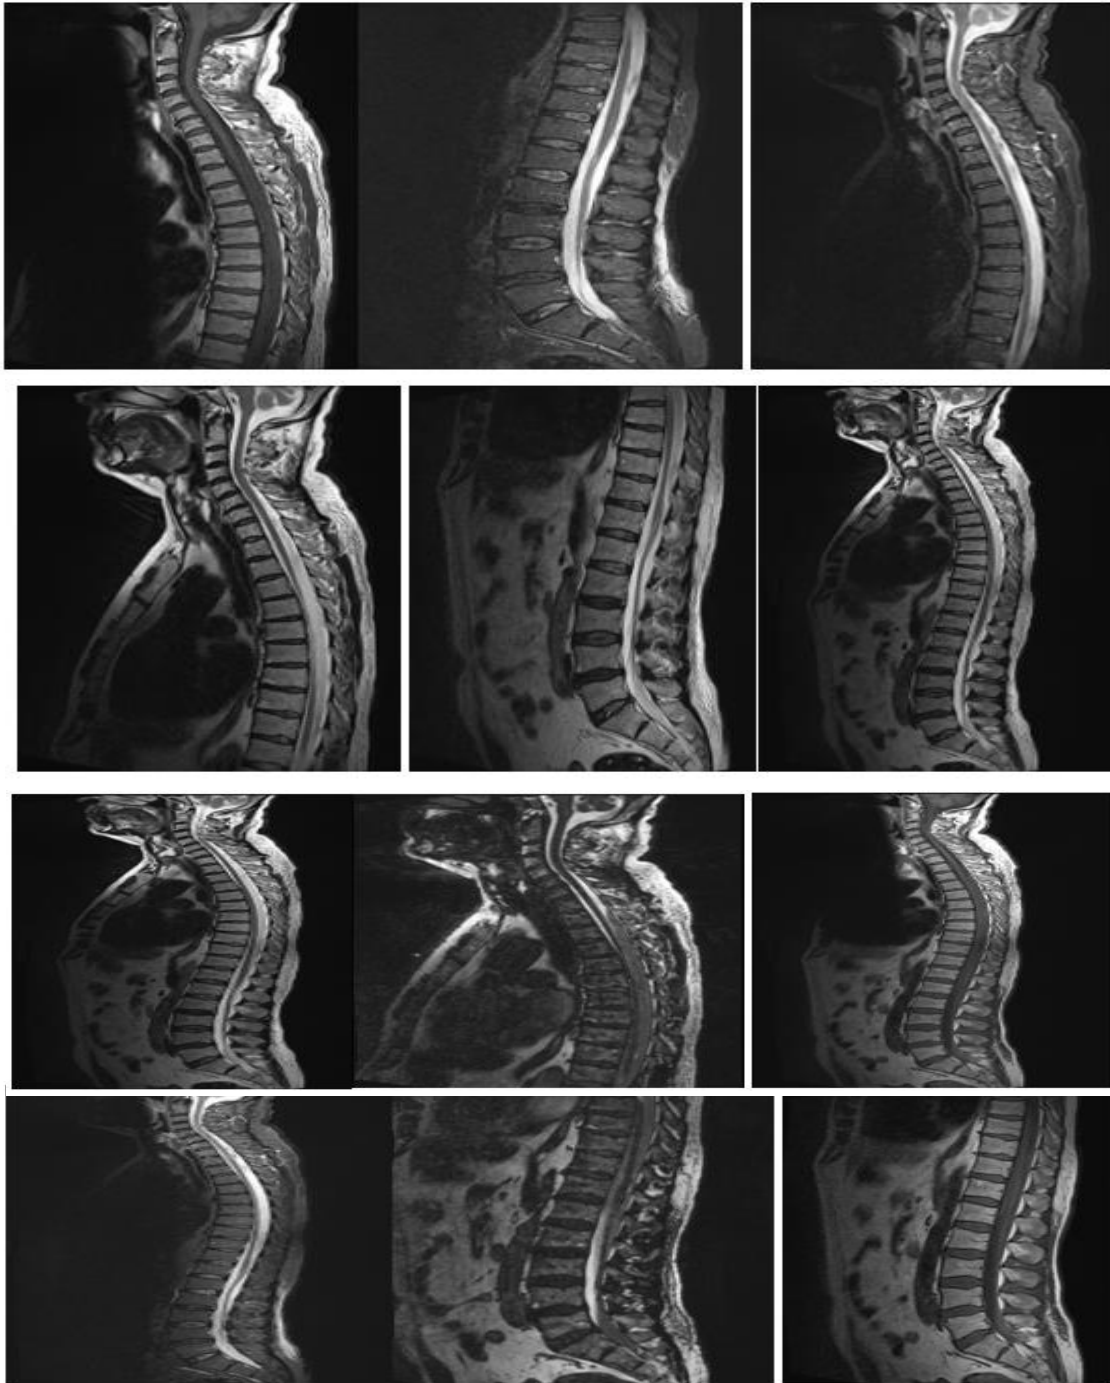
MRI spine different sequences (T1, T2, DWI) of the case No (2).
